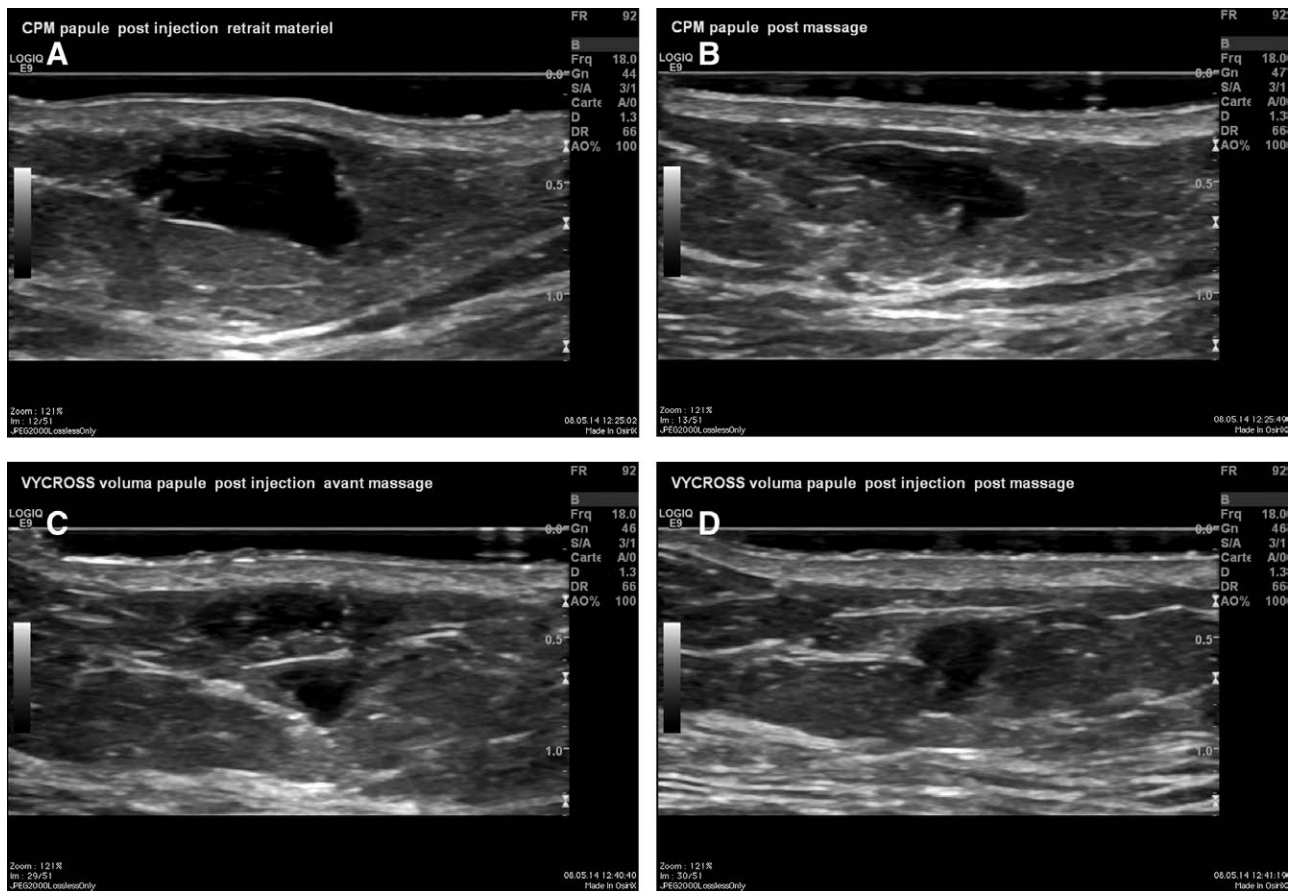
Ultrasound images at day 0 of (A) CPM gel immediately after bolus injection. B, CPM gel after gentle massage. C, Vycross gel immediately after bolus injection. The papule appears to be divided into 2 by fibrous tissue from the fat compartment. In the upper part, air bubbles are visible (white spots). D, Vycross gel after gentle massage. The epidermis appears as a hyperechogenic line at the very top of the image. The dermis appears as the homogeneous, echogenic (bright) structure below this. The injected HA appears as the hypoechoic (dark) area within the hypodermis.
